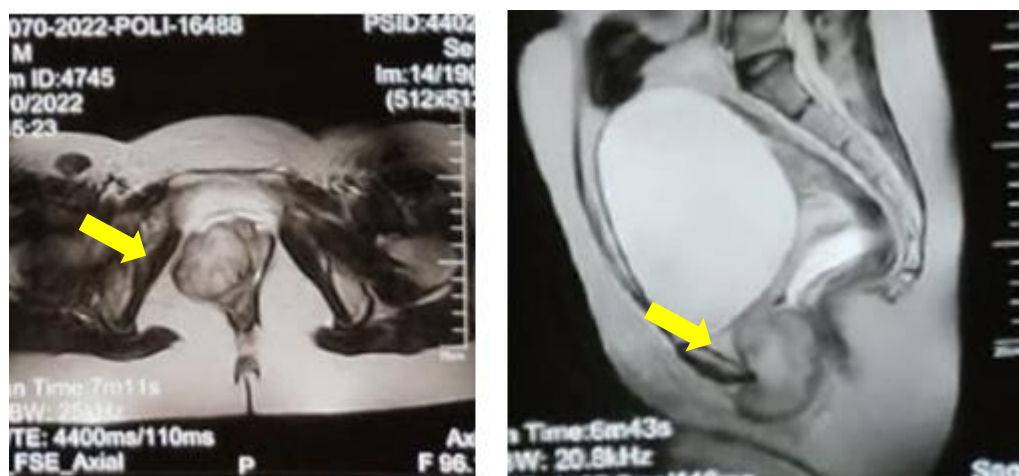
Pelvic MRI results (see yellow arrows).
